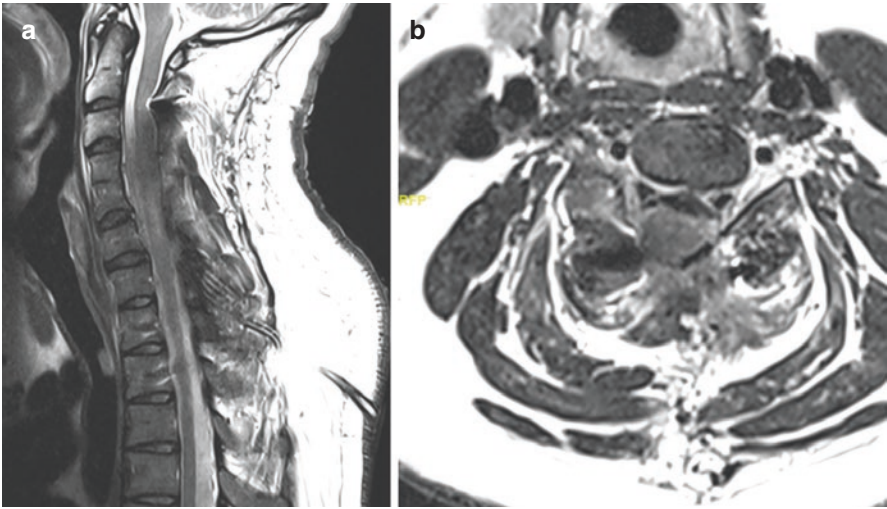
Cervical Spine MRI. Post-operative T2 sagittal (a) and axial (b) MRI cuts revealing a gross total resection of the tumor
